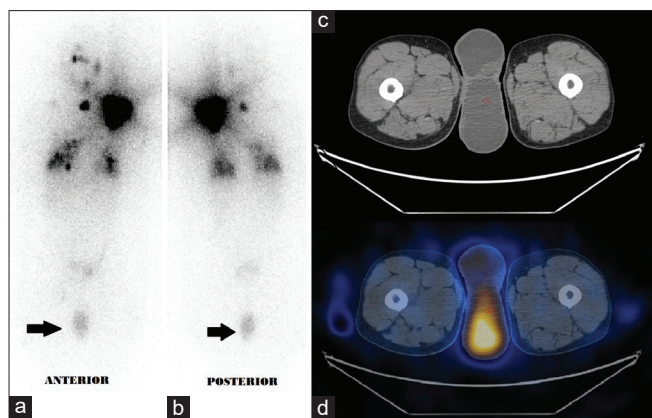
¹³¹I whole body scan images (a and b) in the anterior and posterior view show tracer accumulation in the scrotal region (arrow). Corresponding single-photon emission computed tomography/computed tomography images in the axial section (c and d) show tracer accumulation in hydrocele
